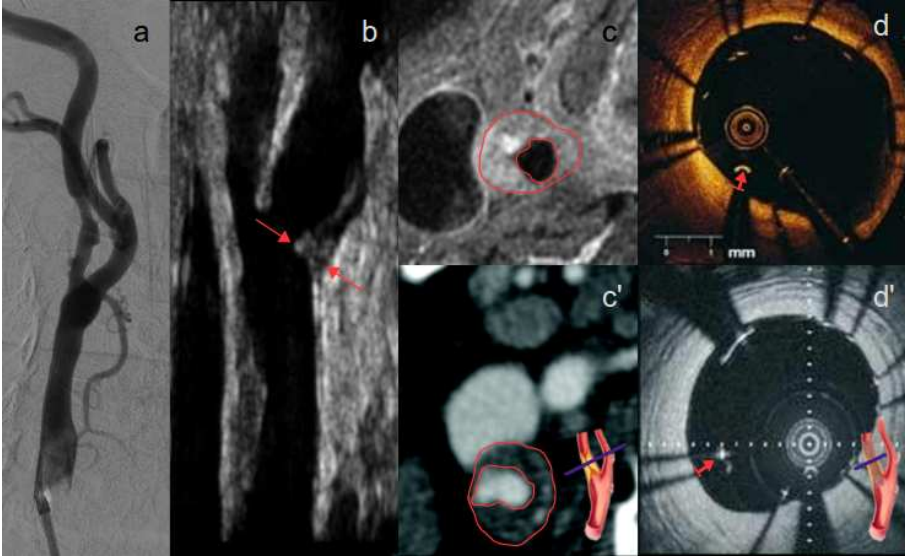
Common imaging techniques for cerebrovascular diseases: *a*: 2D Digital subtraction angiography; *b*: 2D Ultrasounds; *c* and *c'*: Longitudinal cross sectional of Contrast enhanced T1 Magnetic resonance angiography *c* Multi-detector-row Computer tomography angiography *c'* (lumen and external wall are tracked); *d* and *d'*: Intra-vascular Optical Coherence Tomography *d* Intra-vascular Ultrasounds *d'* (arrow indicates the gap between the stent strut and the vessel wall). Adapted with permission from [56], [57], [58], <http://www.examiner.com/>.
